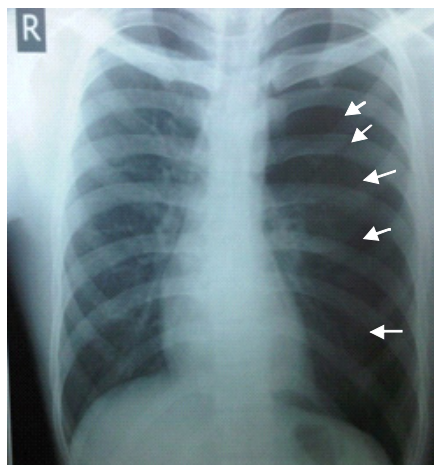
Second chest X-ray (arrows pointing pleural line)
